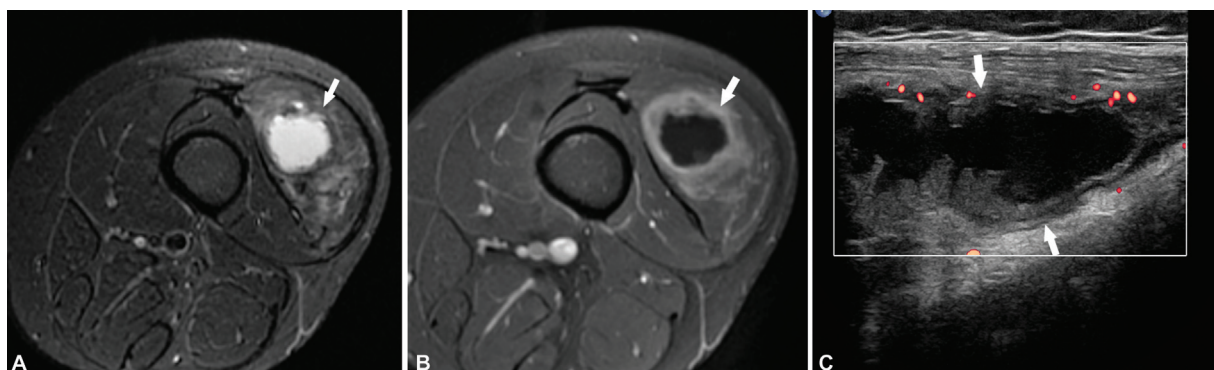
A 46-year-old man with intravenous drug abuse and thigh pain and swelling. (A) Axial short-tau inversion recovery (STIR) and (B) axial T1 fat-suppressed postcontrast magnetic resonance (MR) images show a fluid collection (arrow) with thick peripheral enhancement (arrows) and adjacent muscle edema in the vastus lateralis. (C) Doppler ultrasound image shows a fluid collection (arrows) with thick peripheral rim and enhancement. Aspiration and culture revealed *Staphylococcus aureus* infection consistent with pyomyositis.
